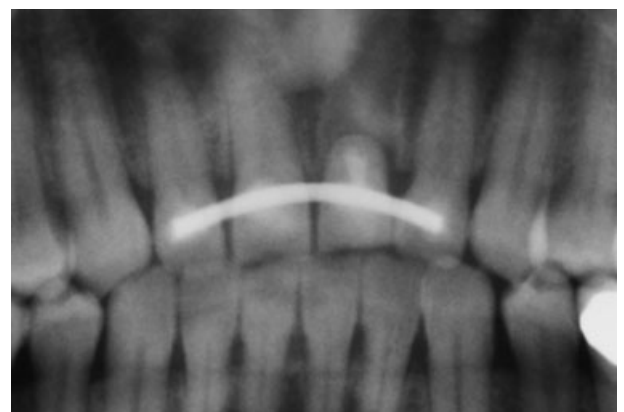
Orthopantomogram after fixation of teeth 12-11-x-22 with a splint.
